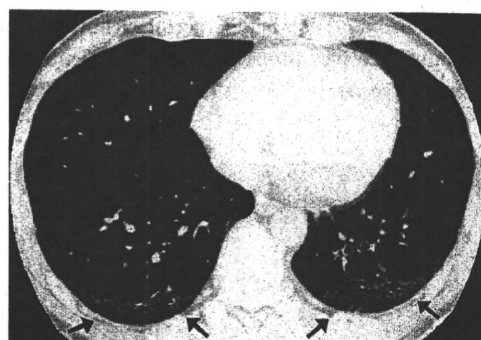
Nonspecific interstitial pneumonia (NSIP) associated with SSc in a 42-year-old man. Transverse thin-section CT (1-mm collimation) through the lower lobes demonstrates intralobular reticular opacity (arrows) with a predominantly peripheral distribution.
